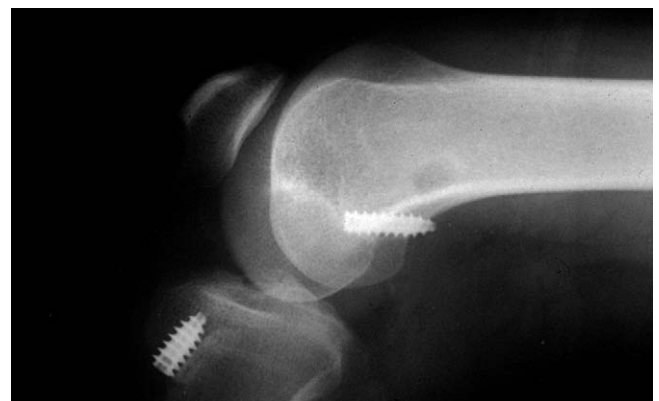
Lateral radiograph showing loss of femoral fixation caused by posterior wall insufficiency.
